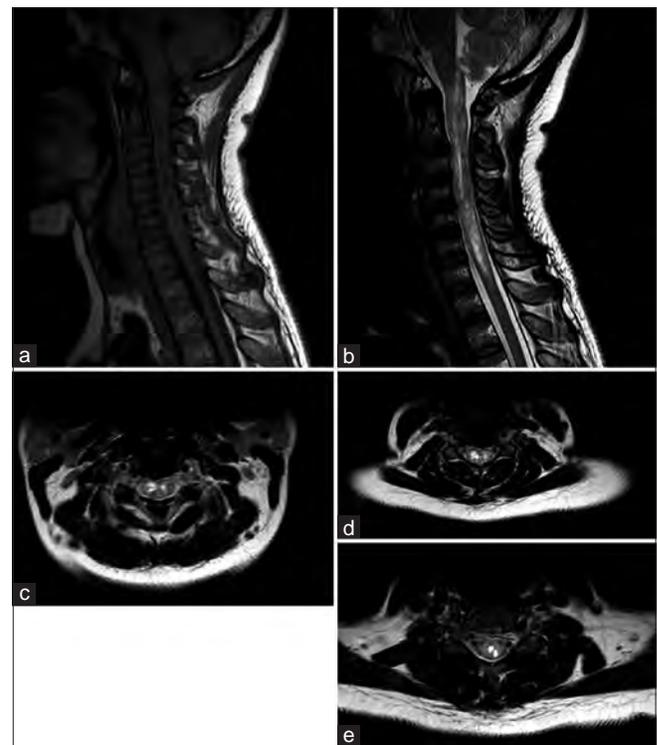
An expansile intramedullary cord lesion within the cervical cord extending from C1 to C7 vertebra. The lesions appear hypointense on T1-weighted image (a), heterogeneously hyperintense on T2-weighted images (b-e) with no signal drop out on STIR images (not shown). There is narrowing of the surrounding cerebrospinal fluid space. Findings were reported as likely spinal astrocytoma
